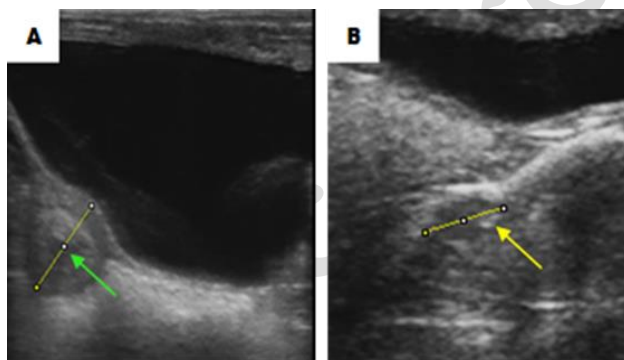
An ultrasound image of the ovaries used to examine the corpus luteum and follicles. A corpus luteum is indicated by yellow arrows, whereas green arrows show the existence of a dominating follicle.
